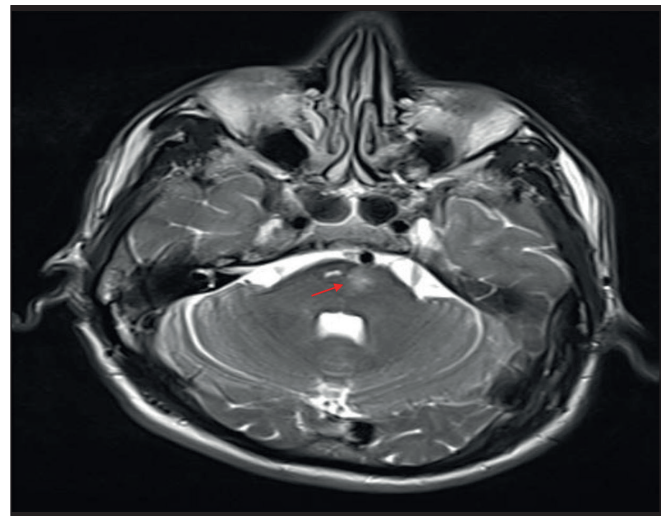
Magnetic resonance image of acute lacunar infarct seen in the pons.
